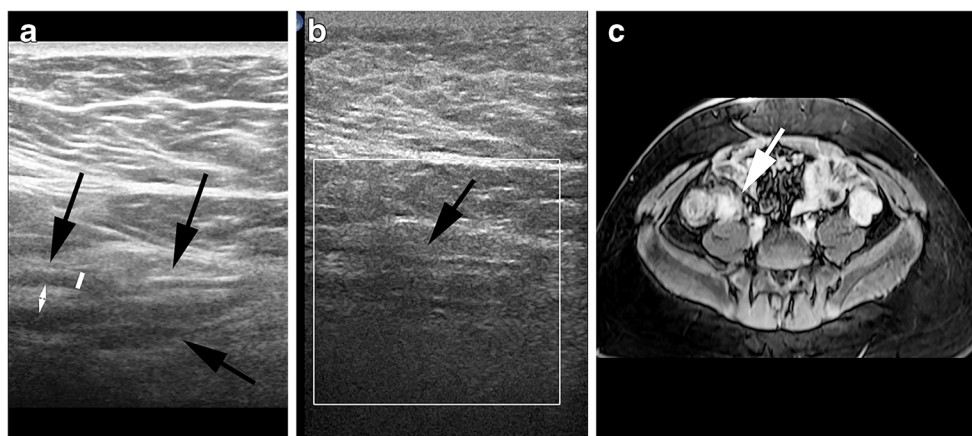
A false diagnosis of normal terminal ileum by ultrasound in an obese 16-year-old girl with Crohn disease. Long-view gray-scale US (a) shows the challenge of penetrating the thick subcutaneous fat with suboptimal demonstration of the terminal ileum (arrows), wall
